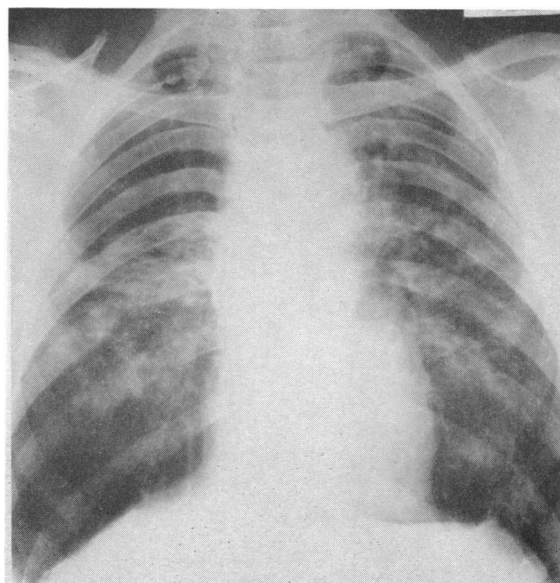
Case 5. Radiograph of chest, April, 1960. Note calcification at right apex and at both hila.
